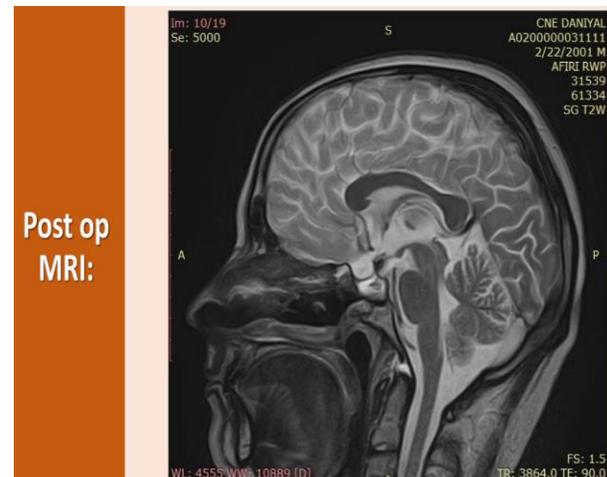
Postop MRI results
